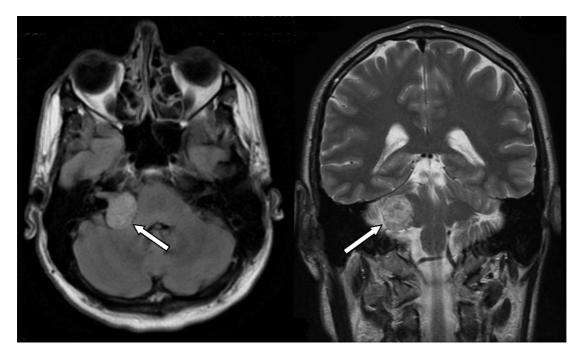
Preoperative magnetic resonance images showing vestibular schwannoma (arrow) exerting pressure on the brain stem.
